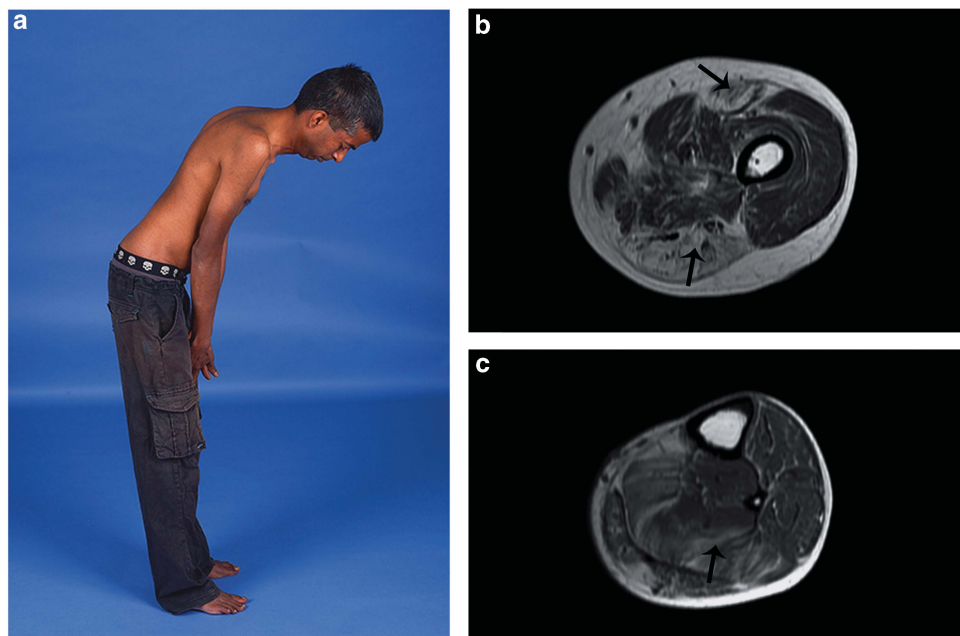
Clinical and radiological features associated with *ACTA1* variant Val154Leu. (a) Patient 1 at age 34 years demonstrating maximum forward flexion of the spine and neck. (b and c) Patient 1 muscle MRI of the left mid thigh (b) showing prominent fat infiltration in the rectus femoris and muscles of the posterior compartment (arrows), and left lower leg (c) showing particular involvement of the soleus (arrow).
